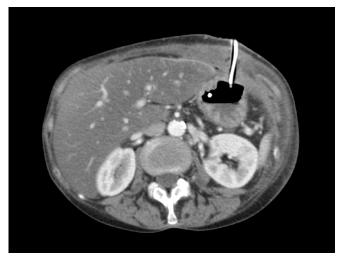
CT scan following PEG-J insertion.
